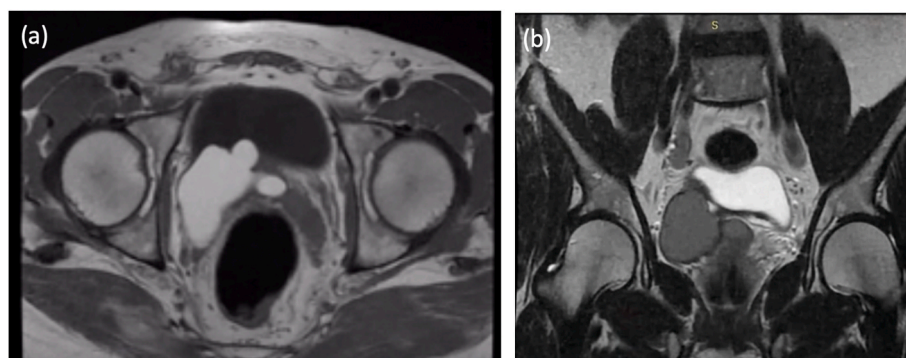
(a) Axial T1-weighted MRI revealed a laterally located cystic lesion in the right seminal vesicle region. (b) Coronal T2-weighted image demonstrating a right seminal vesicle cyst with a remnant ureter.
